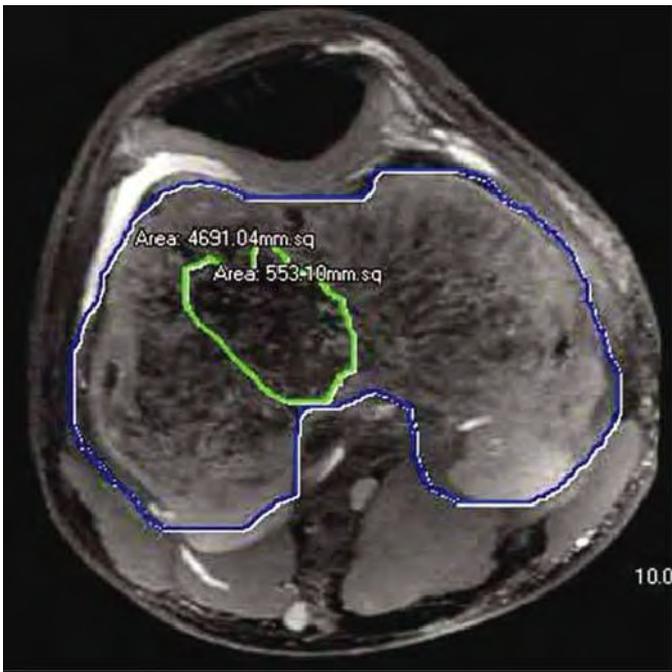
MRI of the distal femoral physis taken 4 months after injury reveals an 11% growth arrest on the central-lateral region of the physis.
